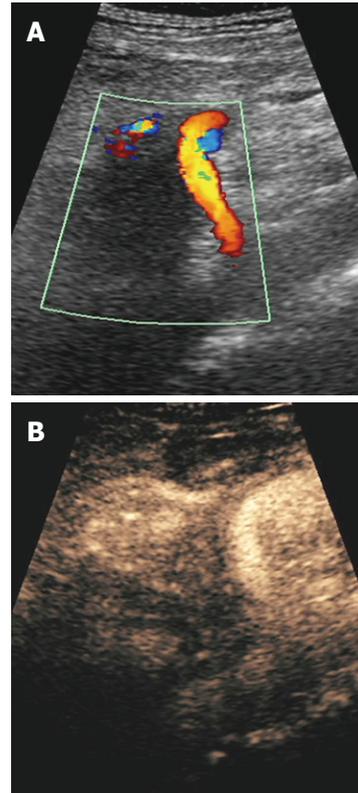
Pancreatic ductal adenocarcinoma after radiotherapy. A: Longitudinal color Doppler scan of the lesion, with hypoechoic infiltration of the superior mesenteric artery; B: Longitudinal contrast-enhanced ultrasonography scan of the hypovascular lesion.
